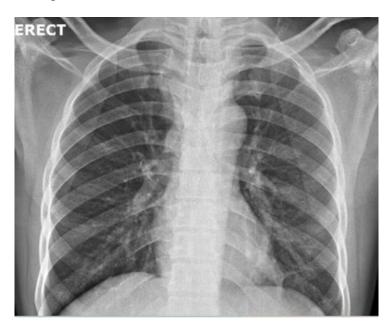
Posterolateral Chest X-ray during admission which shows normal findings
